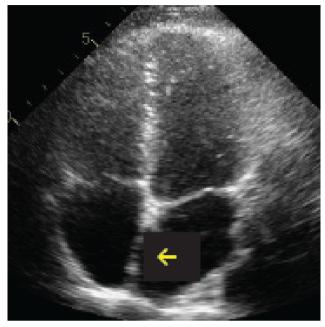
Transthoracic echocardiography showing 4 chamber view. Note that IAS (yellow arrow) is in a vertical position, parallel with the ultrasound beam.
